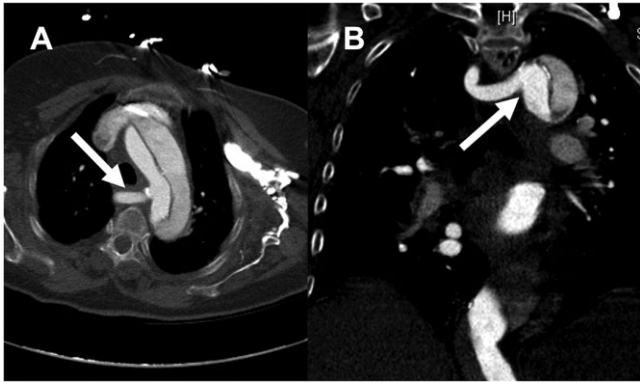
Preoperative computed tomography scan in axial (A) and coronal (B) plane with an aberrant right subclavian artery arising from the true lumen (arrow).
